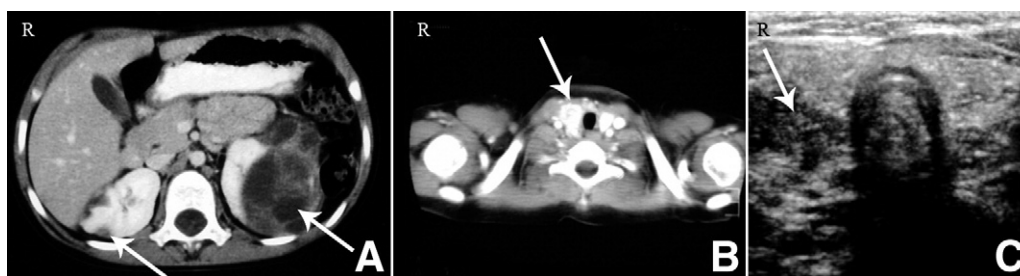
(A) Six years after the diagnosis and treatment of bilateral Wilms tumor (arrows, axial CT) and 2 years after renal transplant, surveillance CT demonstrates a asymptomatic mass in the right lobe of the thyroid (B) (arrow, axial CT). Ultrasound guided biopsy of the hypoechoic solid mass in the right lobe of the thyroid gland (C) (arrow, transverse image from thyroid ultrasound) confirmed papillary thyroid carcinoma. Survivors of childhood cancer, immunosuppressed patients after organ or bone marrow transplant, and those who received thyroid radiation as a result of radiotherapy of another cancer—in this case, whole lung irradiation for pulmonary metastases from bilateral Wilms tumor—are at significantly increased risk for the development of a secondary thyroid cancer.
